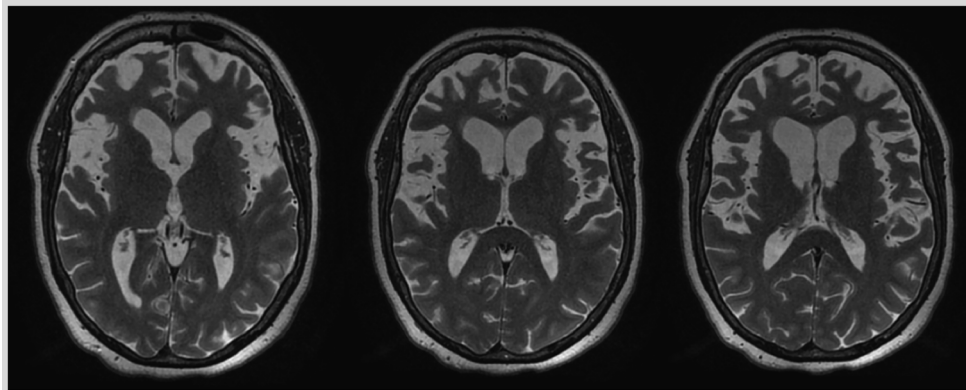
T2-weighted axial MRI shows bifrontal and temporal atrophy in the patient in Case 5-1 with sporadic behavioral variant of frontotemporal dementia.
